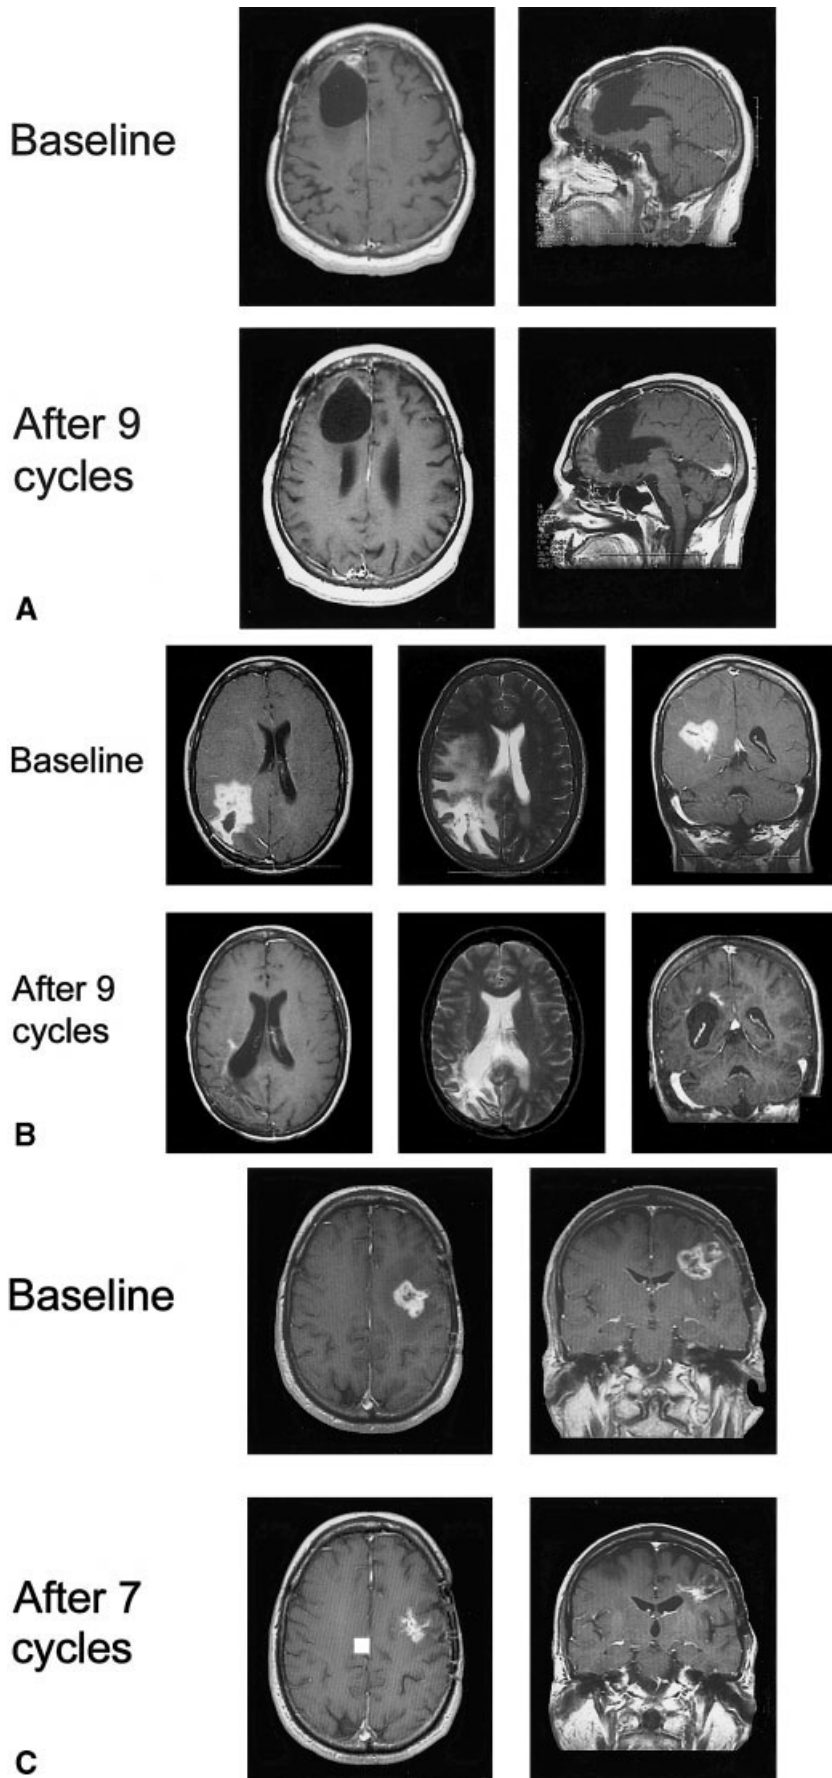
T1-weighted magnetic resonance imaging scan of representative responses to irinotecan plus celecoxib. (A) A patient with recurrent glioblastoma multiforme (GBM) who achieved a complete response. (B,C) Two patients with recurrent GBM who achieved partial responses.
